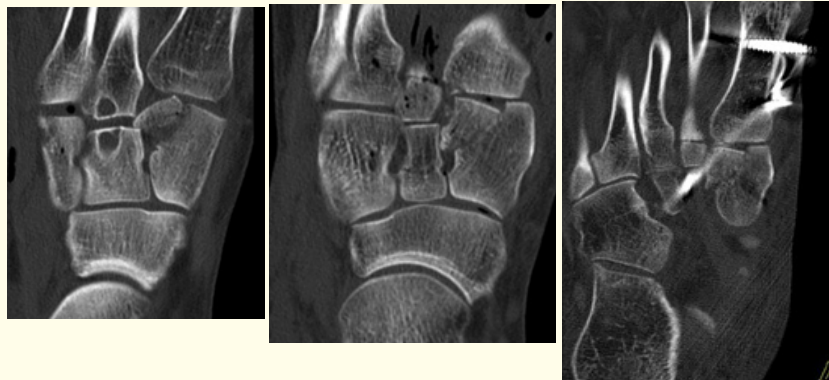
CT scan with complex fracture dislocation of the cuneiforme I. Initial and temporary retention achieved in external fixator and extraarticular screw.
